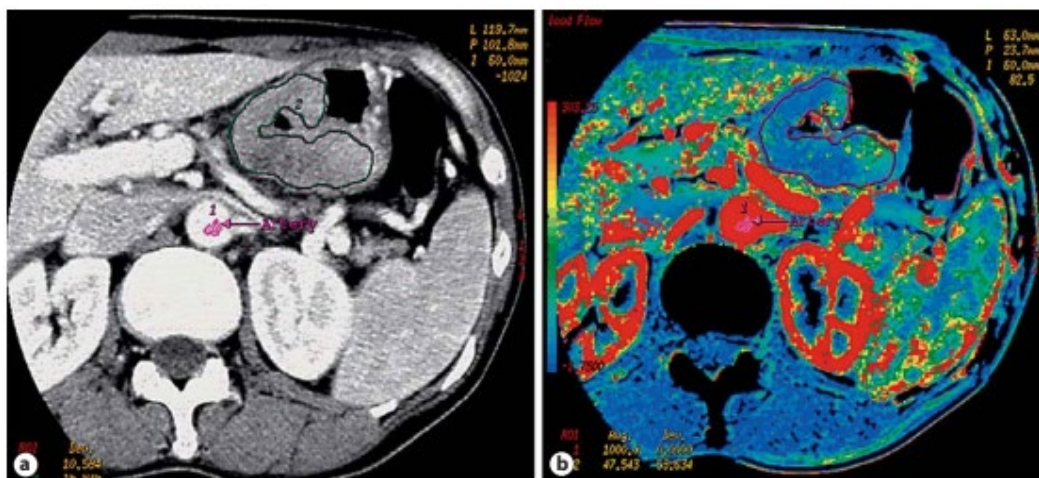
(a) P-CT image of gastric cancer with indication of tumor and (b) Perfusion map of blood flow. An average blood flow of 49.8 ml/min/100 g was calculated [134].
